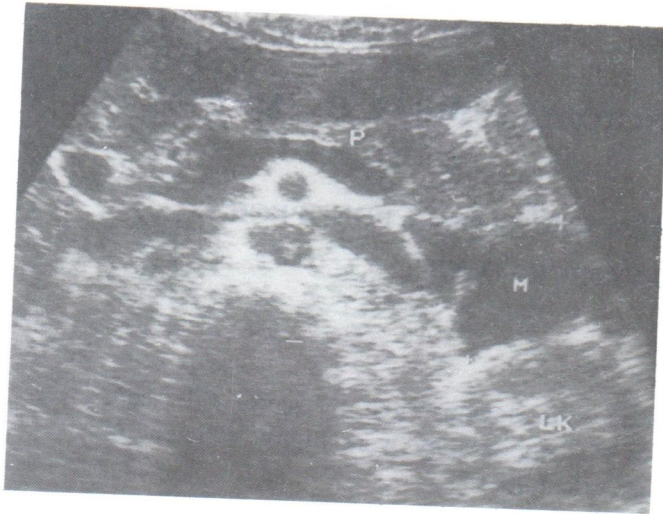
Sonogram in trasverse plane showed a cystic mass with septations located at dorsal aspect of the pancreatic tail and anterior to left kidney.
